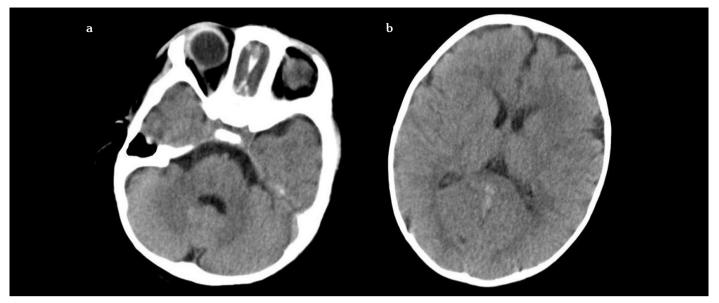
a, b. Axial non-enhanced CT images at the level of the pons (a) and lateral ventricles (b) does not show any abnormality CT: computed tomography
